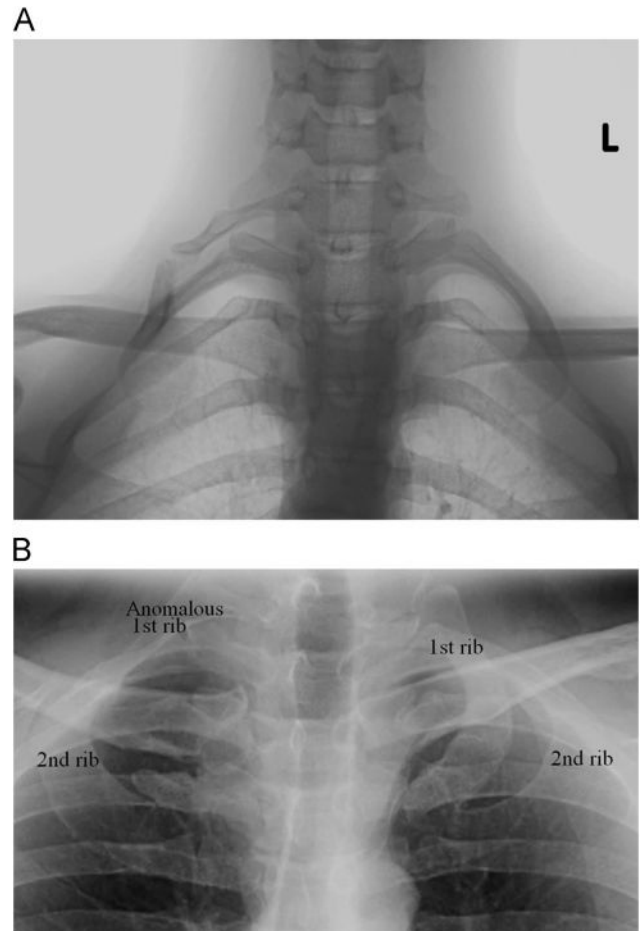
(A) X-ray of complete cervical rib with true joint to first rib on right; (B) x-ray of anomalous first rib on right.
